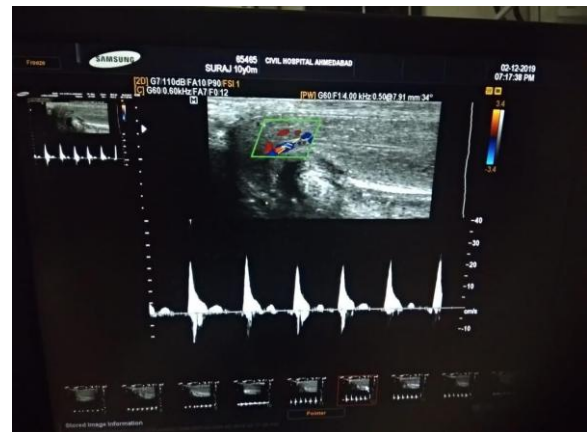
Normal penile Doppler
